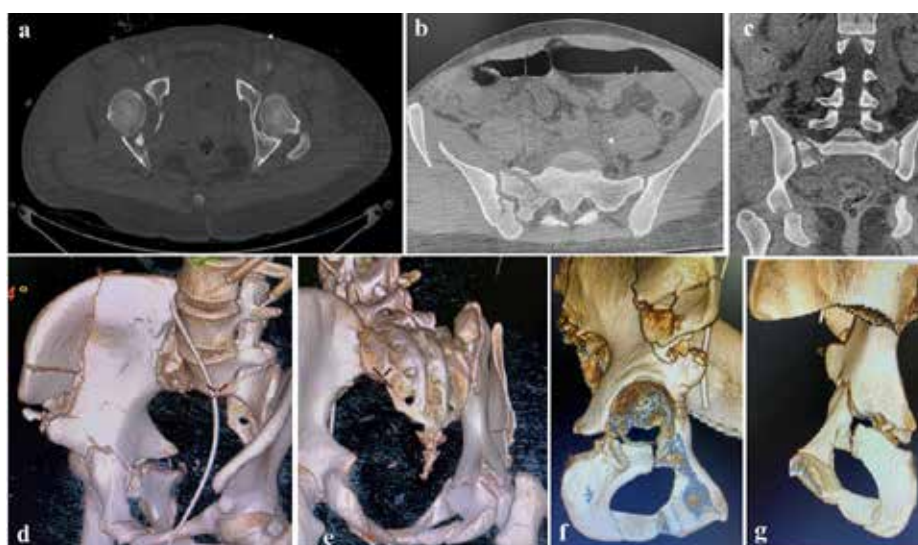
Case 3 CT scan. *a) axial view- Quad is floating, b) comminuted SIJ with intact posterior elements and fractured ilium, c) coronal view showing SIJ disruption and posterior column displacement, d) 3D Recon quad in 2 major pieces, e) posterior column with part Quad, f) Juxtatectal fracture-quad near major sciatic foramen stable in continuity with comminuted iliac bone, g) quad in a large piece but has lost its continuity with iliac bone, acetabular brim in front and ischial tuberosity-posterior column behind*
